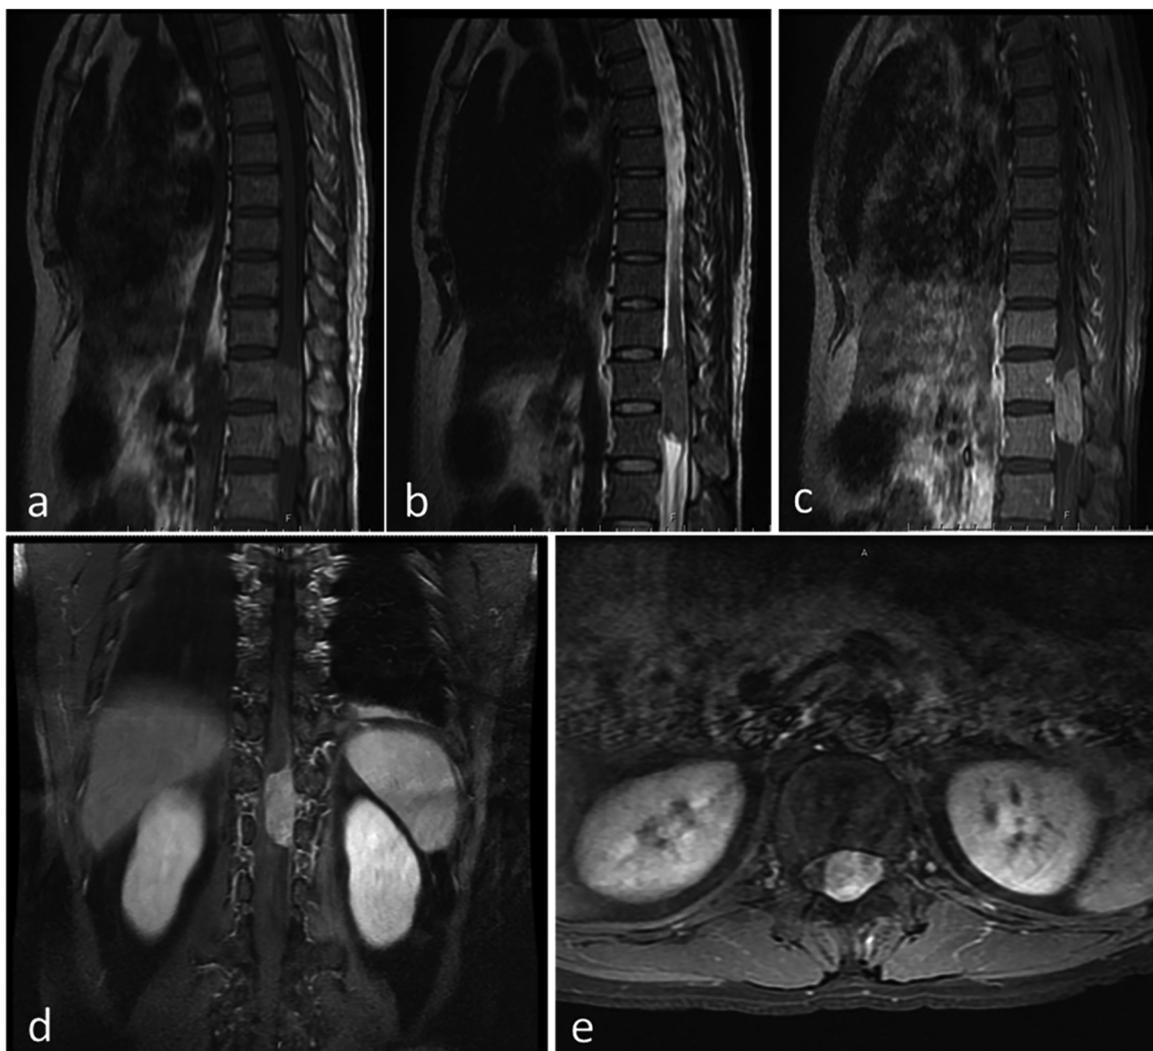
Case 4. Preoperative magnetic resonance imaging (MRI) of the thoracic and lumbar spine revealed a lesion at the T12-L1 level. T1-weighted sagittal (a) view shows a hyperintense signal of the lesion. T2-weighted sagittal (b) view shows an isointense signal of the lesion. Enhanced MRI sagittal (c), coronary (d), and axial (e) views show a significantly enhanced intradural mass.
